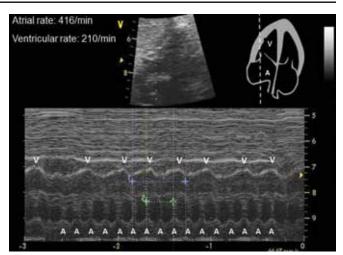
M-mode Doppler technique documents fetal atrial flutter with variable block
